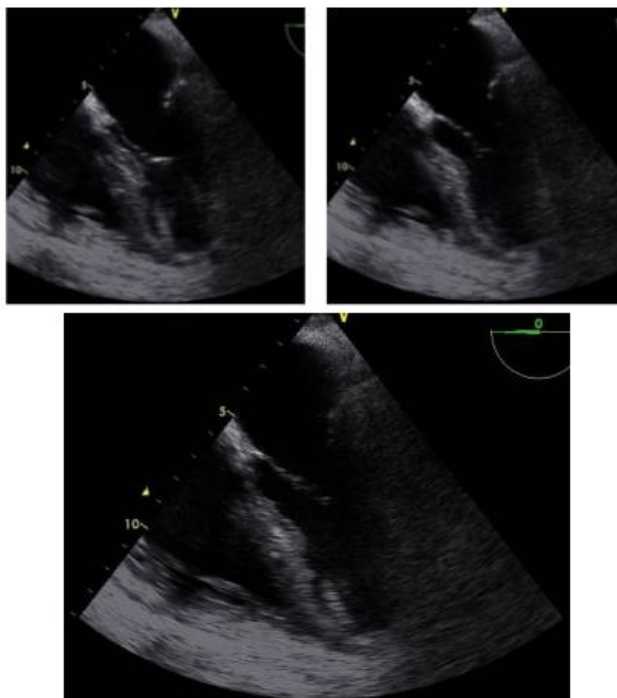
Intraoperative Transesophageal Echocardiogram
